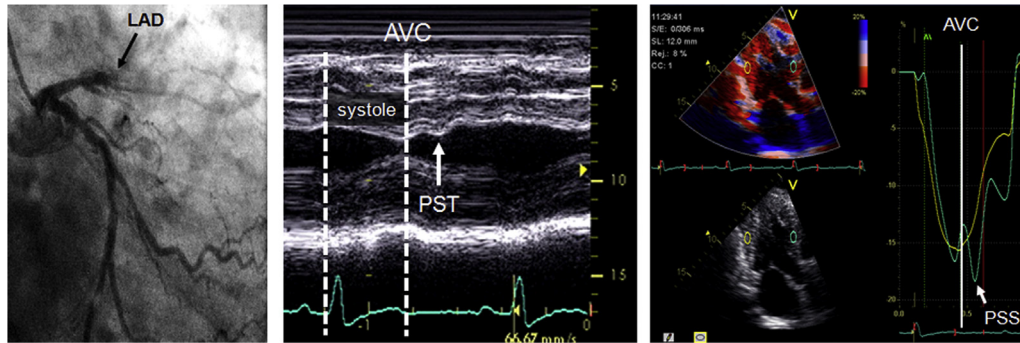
Altered deformation of the septum in a patient with suspected coronary artery disease. The patient had a two-dimensional echocardiogram at rest. M-mode recording (middle panel) showing the ‘double peak’ contraction pattern of the septum (white arrow pointing at post-systolic thickening of the septum). Tissue Doppler-derived segmental longitudinal strain curves (right panel) of normal posterior wall (yellow curve with a single peak systole) and ischemic septum (double peak green curve with the post-systolic peak occurring after the aortic valve closure). Coronary angiography (left panel)—proximally occluded (black arrow) left anterior descending coronary artery (LAD). AVC, aortic valve closure; PSS, post-systolic shortening; PST, post-systolic thickening. (Adapted from Nešković AN, Flachskampf FA, Picard MH (eds). *Emergency Echocardiography*, 2nd Edition. CRC Press, Taylor & Francis Group, Boca Raton, London and New York, 2017, ISBN - 13: 978-1-4822-4385-7 (Pack-Book and Ebook)).
